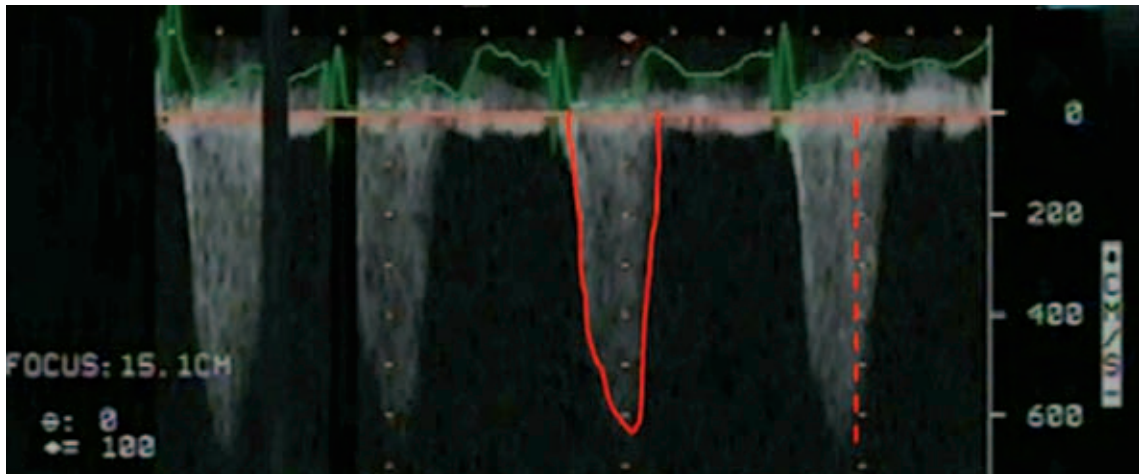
Quantification of high velocities across left ventricular outflow tract by Continuous Wave Doppler in the transgastric long-axis view (peak velocity approximately 6,5 m/sec).
